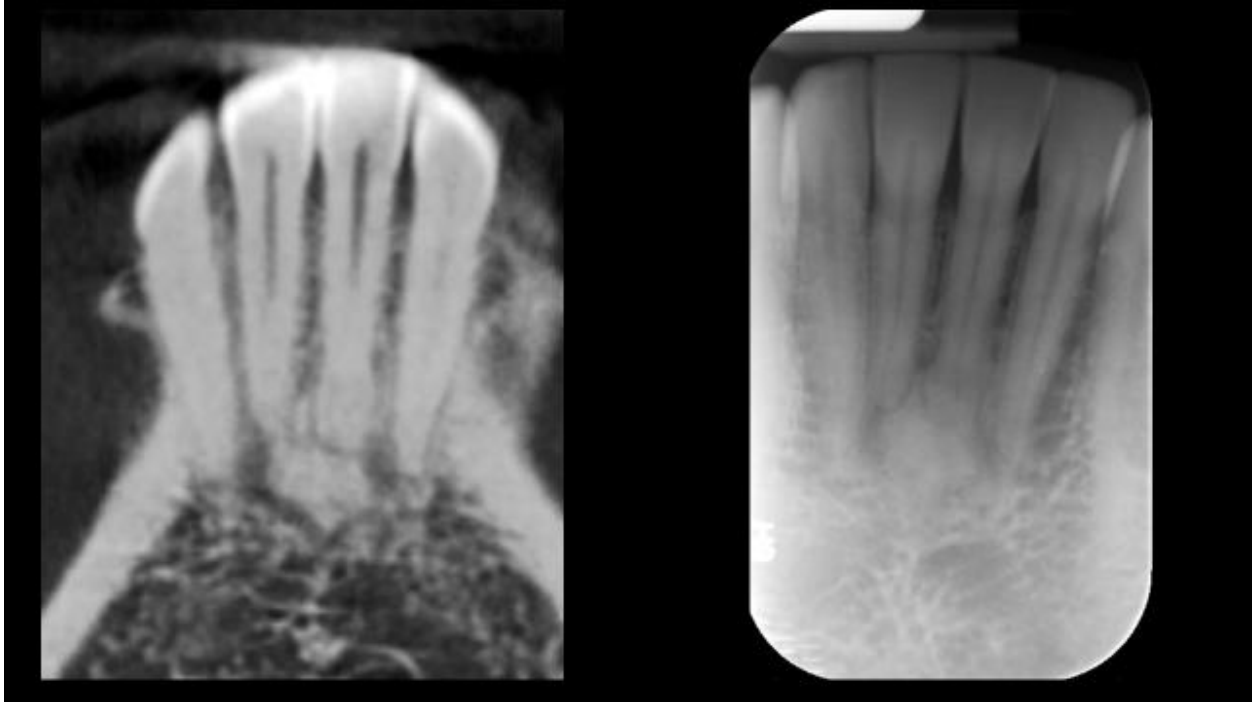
Periapical Cemento Osseous Dysplasia CBCT (left) visible on PA (right)
